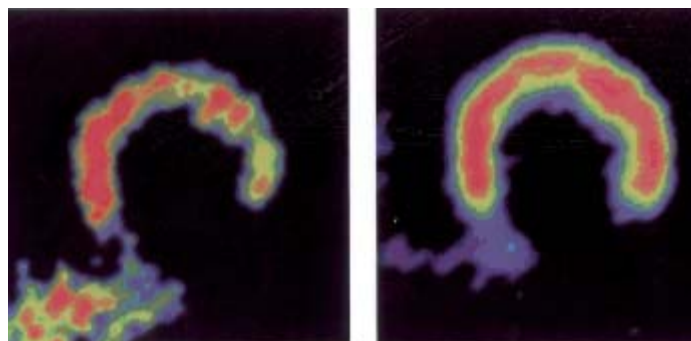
Short axis slices of the left ventricle using PET scan. (Left) Normal to mildly reduced ¹³N-ammonia uptake in the anterior wall and absent perfusion in the posterior wall. (Right) Increased FDG uptake in the anterior wall suggestive of hibernating myocardium, and absent uptake in the posterior wall suggestive of necrosis.
